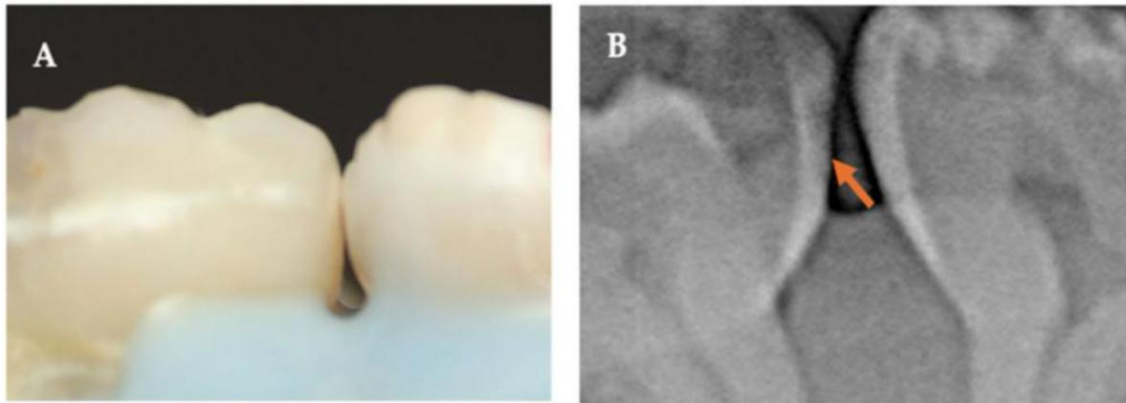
Bitewing radiography revealed an artificial caries lesion (Tashkandi et al., 2025)
